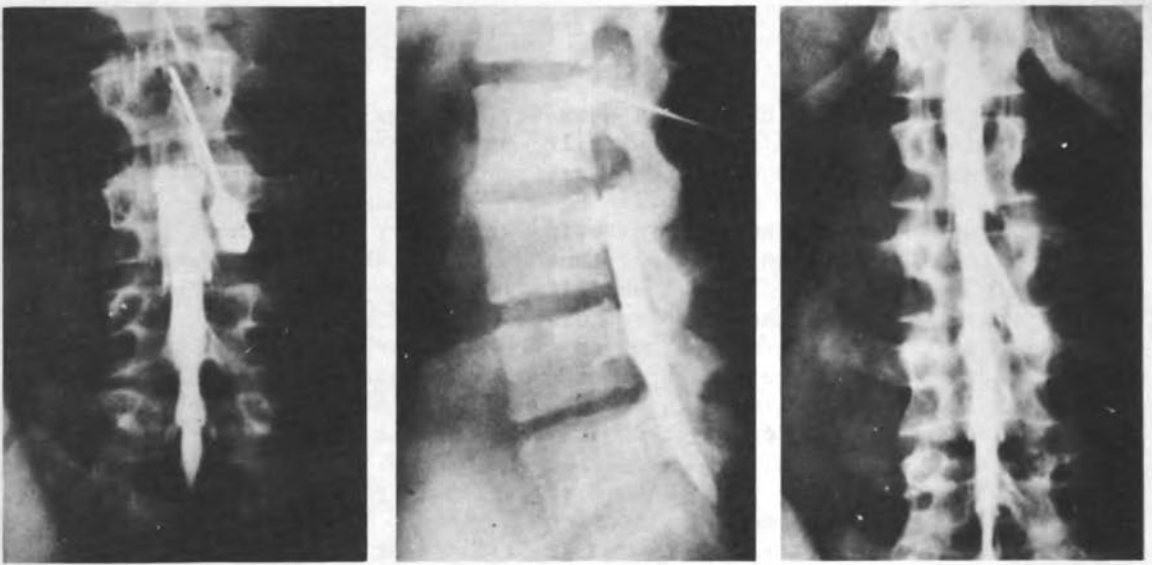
A (left). A 16 year old boy with right-sided sciatica and low back pain. The plain film roentgenograms were considered to be normal. Erect anteroposterior myelogram, after the installation of 4 cc. of Pantopaque, indicates narrowing of the thecal sac. B (center). Lateral myelogram of the same patient. C (right). During strain, the thecal sac contracts and the level of the Pantopaque column reaches the 12th thoracic vertebra. At operation this patient had a right laterally situated herniated disc at L5 S1 interspace.
